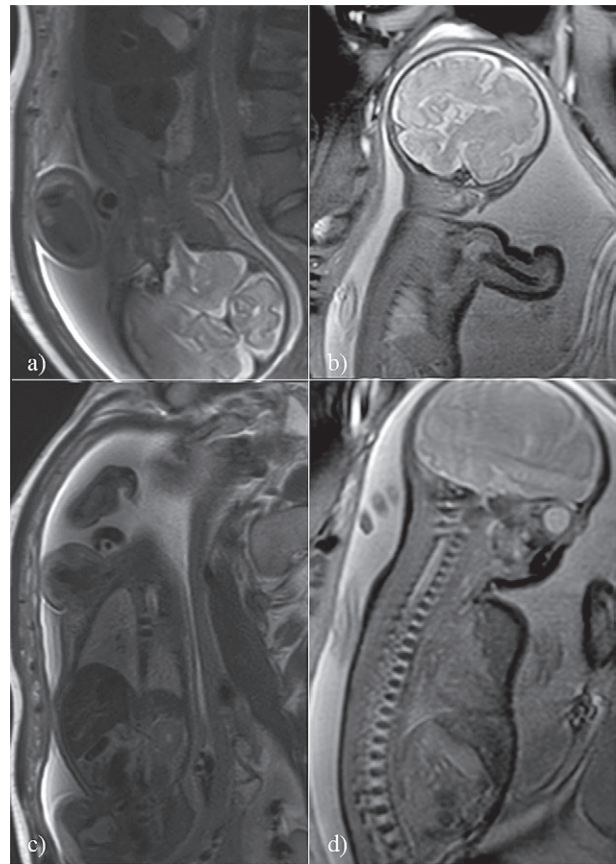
Fetal MRI: a) BTFE SPIR COR T2 – weighted sequence in a fetus with achondroplasia reveals narrowing of the foramen magnum; b) COR TSE T2 – weighted sequence in a fetus with osteogenesis imperfecta confirms rhizomelic bowed humerus; c) SAG TSE T2 – weighted sequence in a fetus with osteogenesis imperfecta confirms normal lung volume; d) COR TSE T2 – weighted sequence in a fetus with achondroplasia showing normal spine
